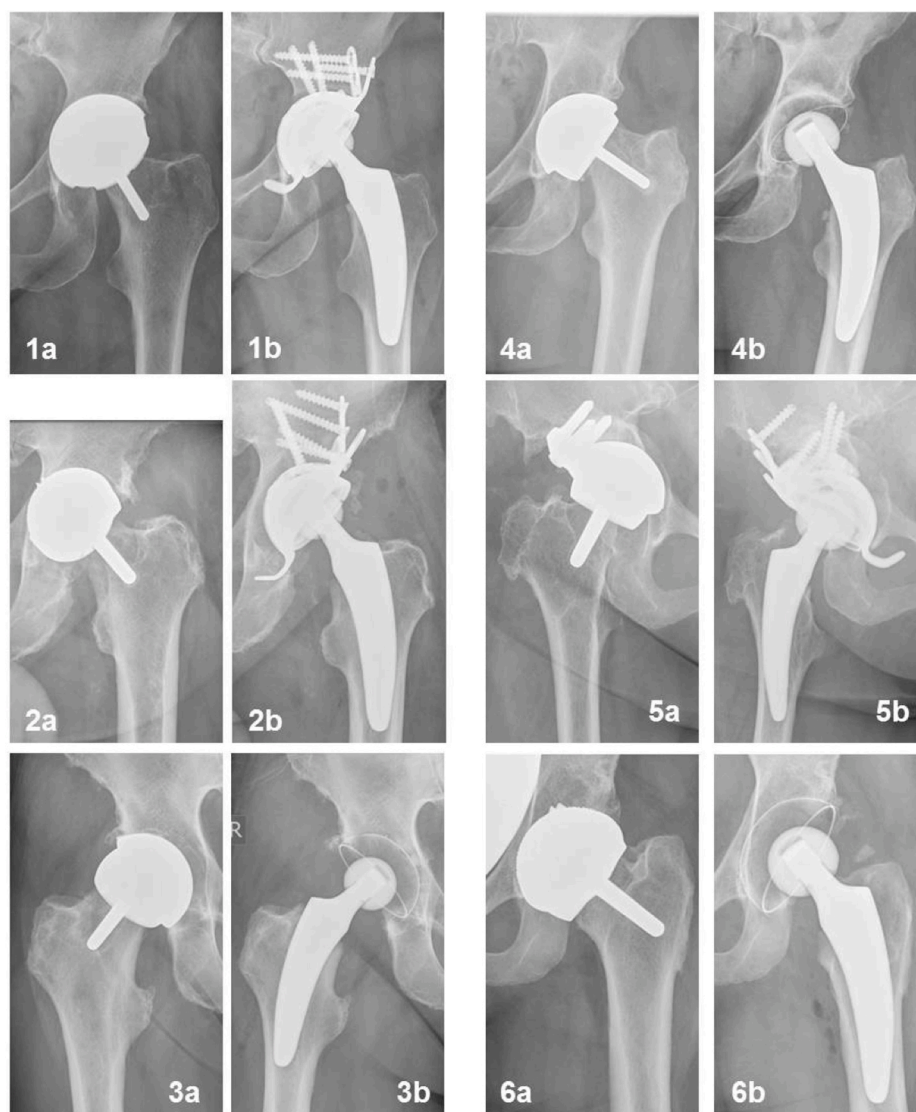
Radiographs of all patients (1–6; a: preoperatively, b: postoperatively).
